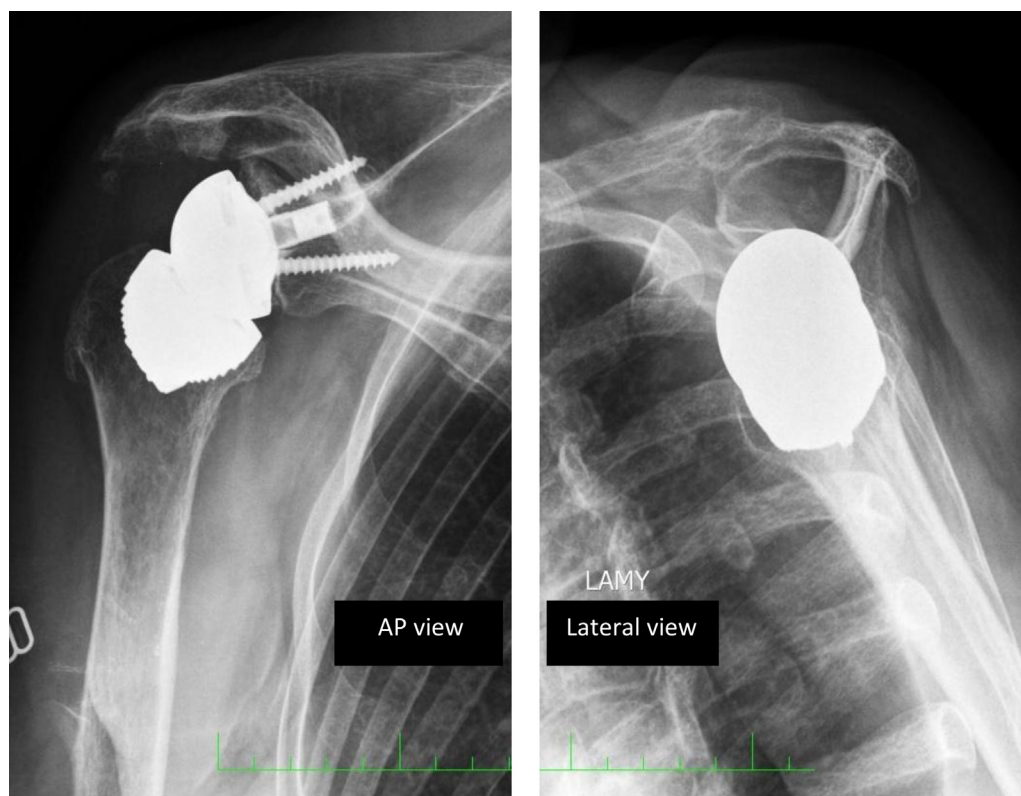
Standard postoperative x-rays of reverse shoulder prosthesis without stem.
